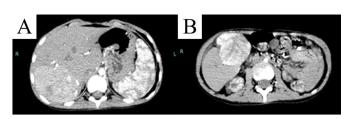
CT images of the two hepatic lesions hepatocellular carcinoma (HCC) in (A) S7 and (B) S5-S6 liver segments, respectively.
